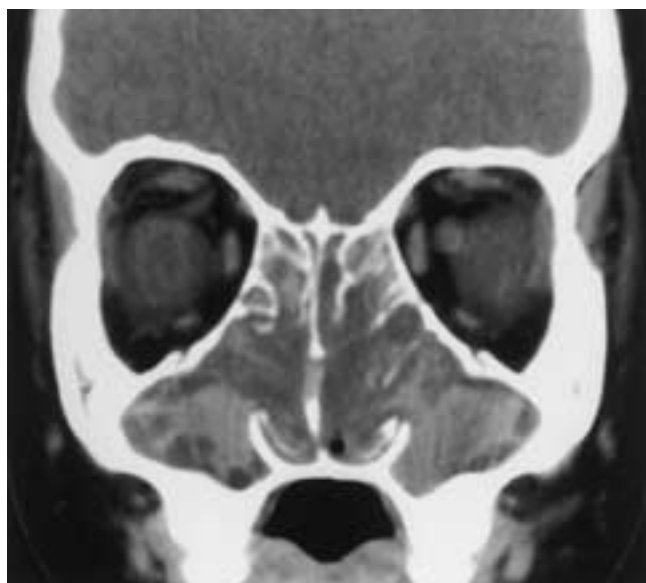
Cystic fibrosis in a teenager with nasal obstruction and a chronic cough. Coronal CT reveals foci of high density due to inspissated secretions with polypoid mucoperiosteal thickening within the paranasal sinuses protruding into and obstructing the nasal cavity.
